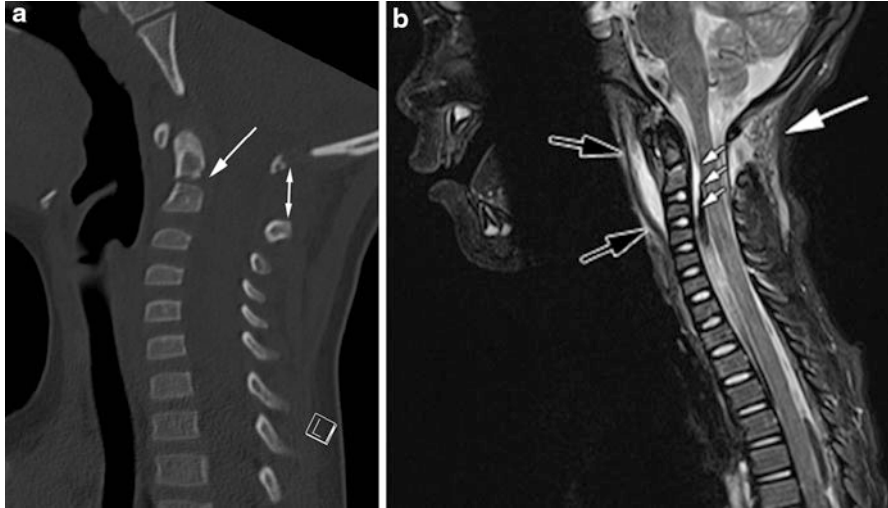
Odontoid fracture. 3-year-old following a motor vehicle accident. A sagittal noncontrast CT image (a) shows a fracture (*white arrow*) at the base of the dens ossification center (type II odontoid fracture). The tip of the dens is tilted anteriorly. There is also splaying of posterior elements of C1 and C2 (*double-headed arrow*) indicating posterior ligamentous injury. A T2-weighted sagittal MR image obtained using a technique that suppresses signal from fat (b) shows edema (*white arrow*) within the posterior interspinous ligaments at C1–C2 consistent with ligamentous injury. There is an EDH (*small white arrows*) which narrows the spinal canal; however, the spinal cord itself demonstrates normal signal intensity without evidence of acute injury. There is also a fluid collection within the retropharyngeal soft tissues (*open arrows*)
